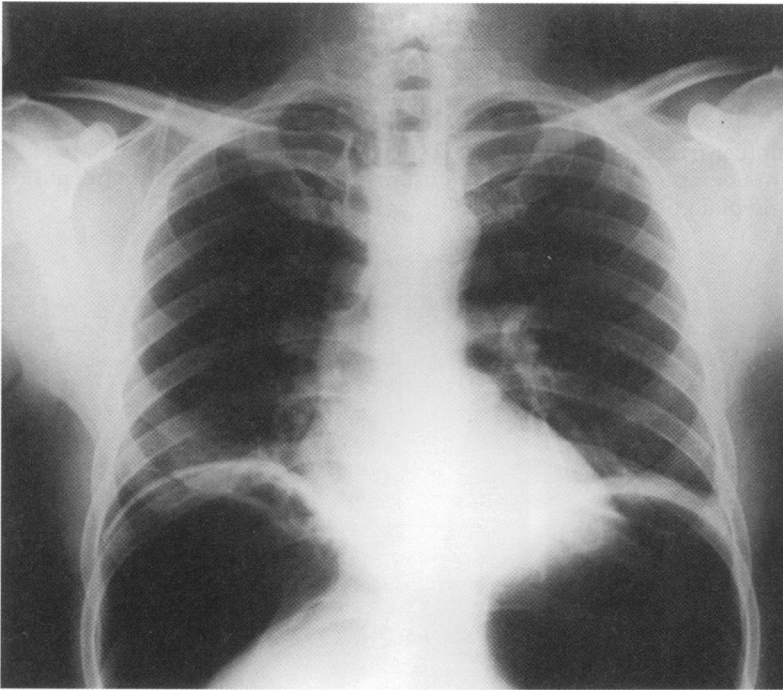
Chest radiograph showing a large volume of free intraperitoneal gas below both hemidiaphragms.
